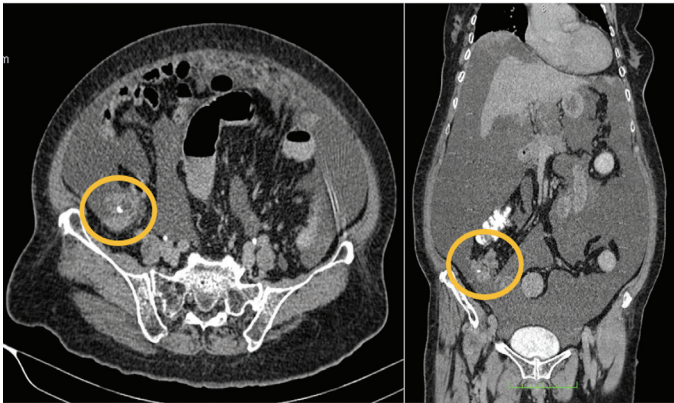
Abdominal CT scan with contrast showing massive ascites, insinuating into the subdiaphragmatic recesses, causing elevation of both hemidiaphragms. Encircled is the distended appendix measuring 2.1 cm (yellow circle) with irregular wall thickening and an appendicolith within its lumen.
